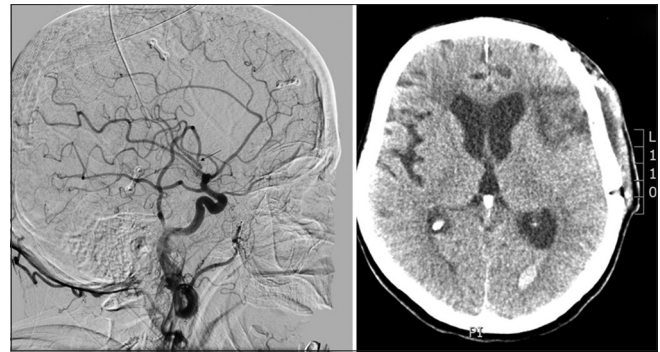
Postoperative digital subtraction angiography and multislice computed tomography on the day of discharge, anastomosis is marked by arrow
